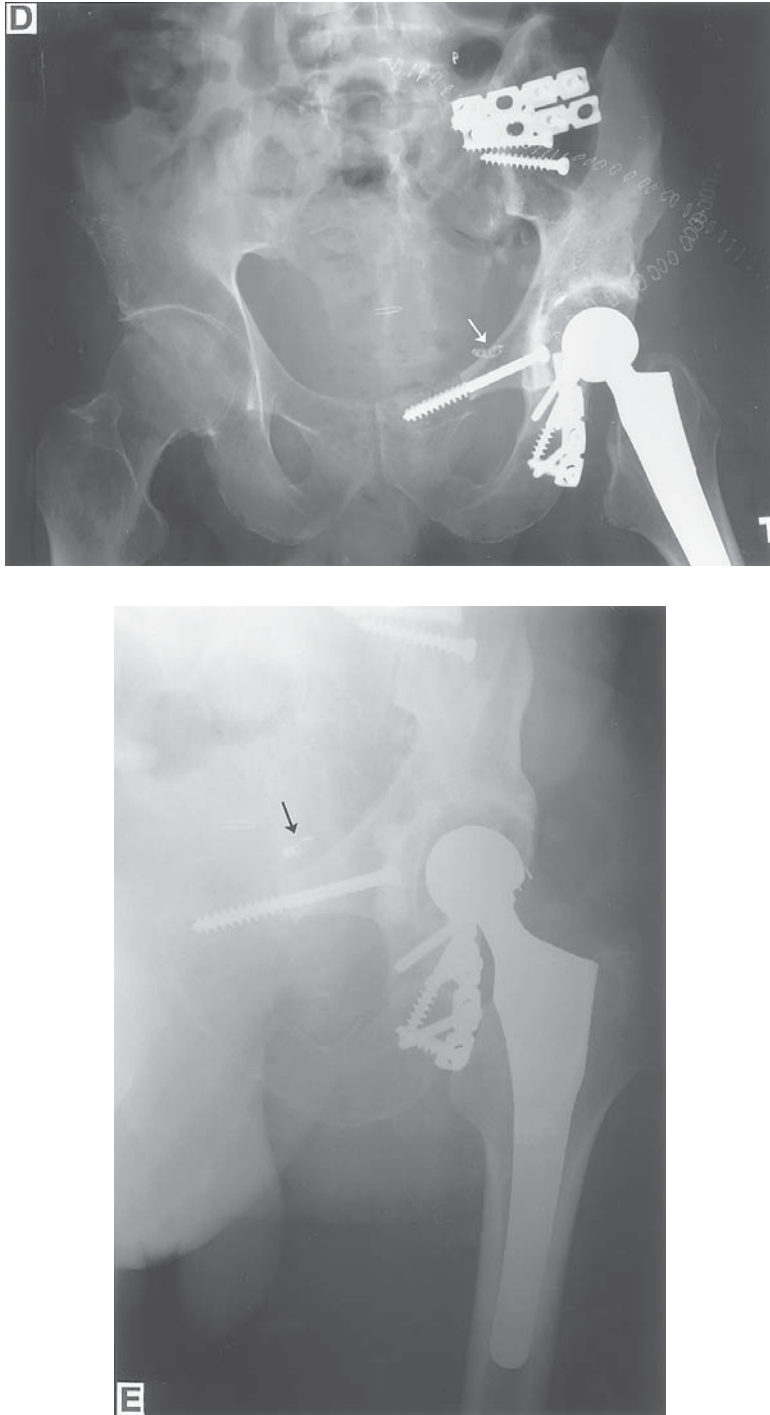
(Continued). (D) Postoperative radiograph. Arrows point to embolization coils placed preoperatively. (E) Radiograph at 14 mo with patient ambulatory with a cane, but significant limp secondary to loss of gluteus medius from resection of involved tumor mass.
